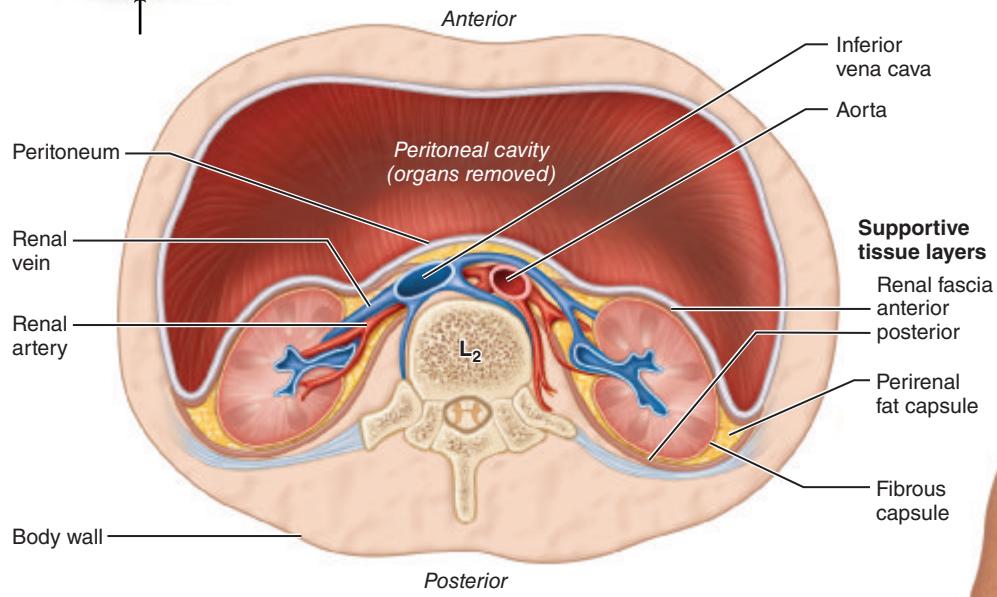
Position of the kidneys abutting the posterior abdominal wall. (a) Cross section viewed from the inferior direction. Note the retroperitoneal position and the supportive tissue layers of the kidney. (b) Posterior in situ view showing relationship of the kidneys to the ribs. (c) Computed tomography (CT) scan through the abdomen showing a view similar to (a), peritoneal organs visible.
